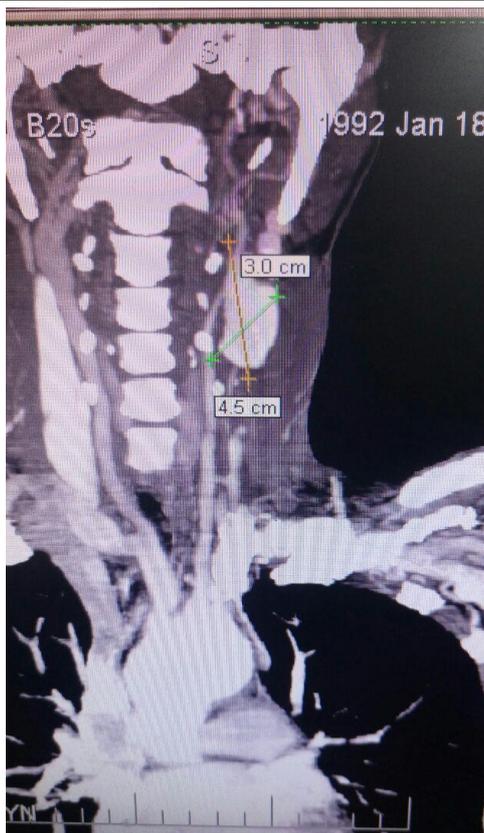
CT scan of the left cervical pseudoaneurysm
